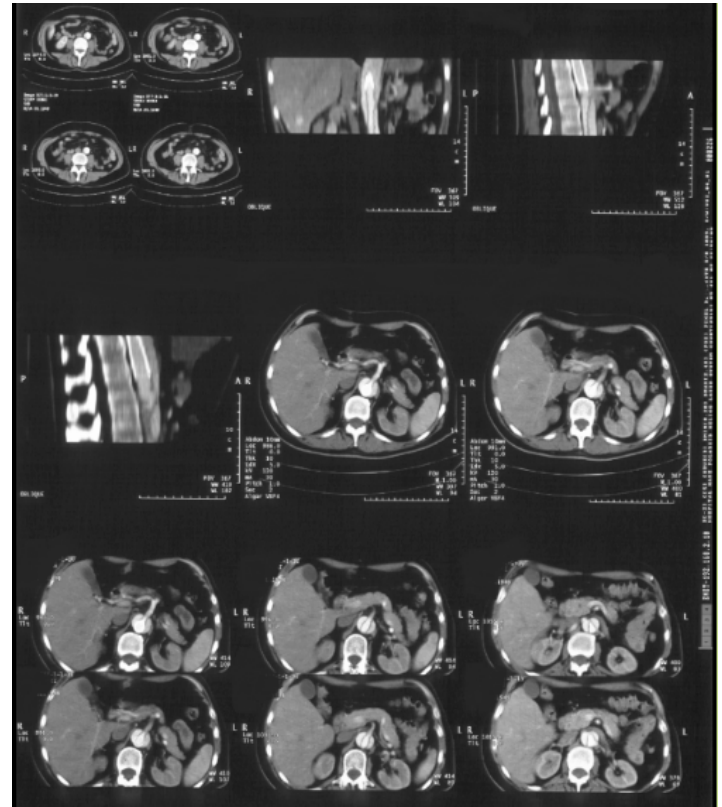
Completely centralized blood flow after endovascular procedure on CT.
